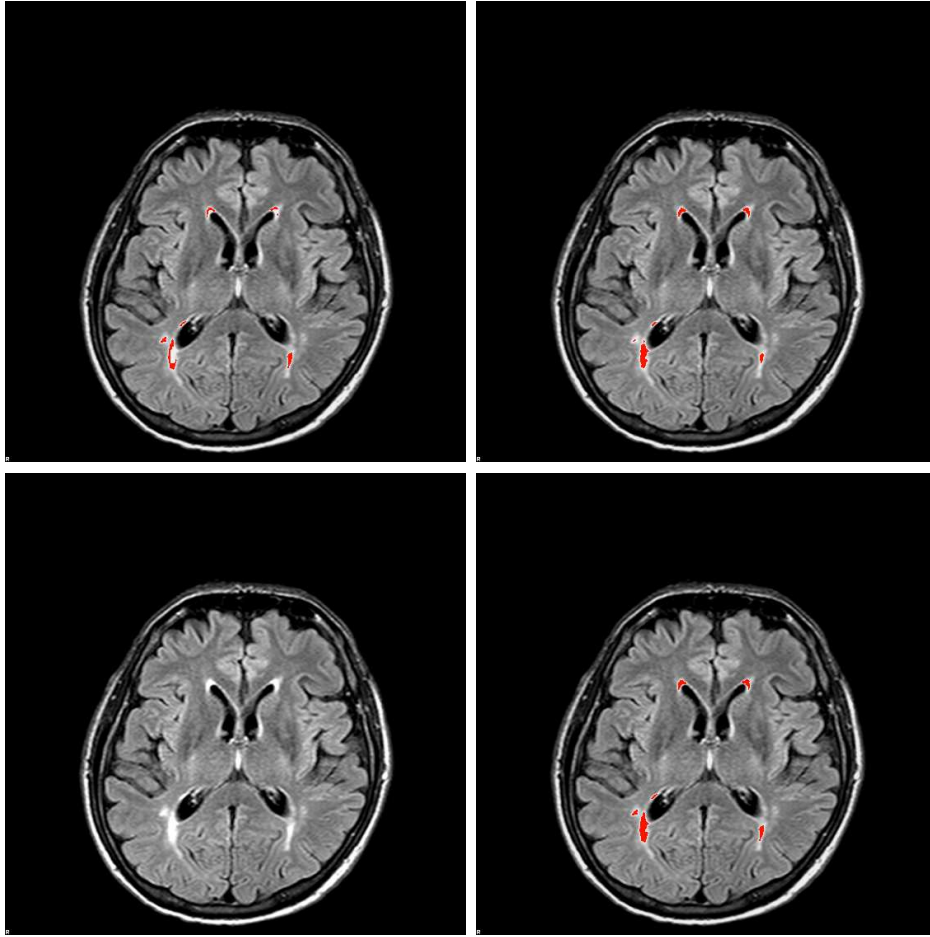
White Matter Hyperintensity Masks on FLAIR Image. On the upper left WMH from white matter is in red. On the upper right WMH from white and gray matter is in red. On the lower right WMH combined from both is in red.
